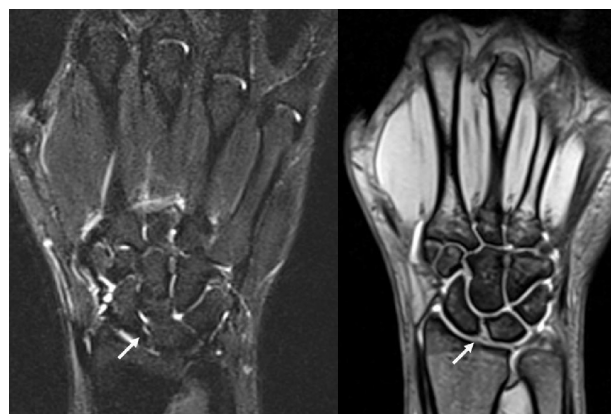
MRI – partial scapholunate ligament tear
